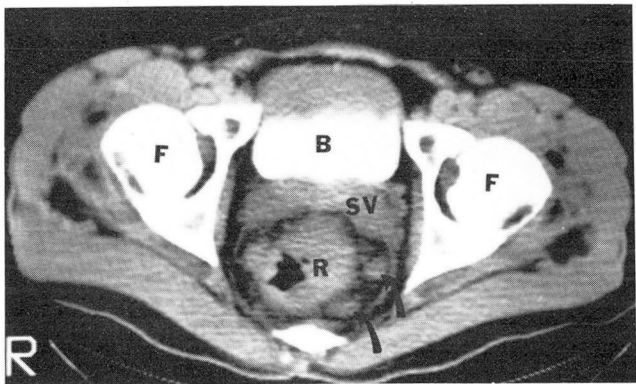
Transverse CT scan of the pelvis. Contrast media was given intravenously and was identified within the urinary bladder (B). The seminal vesicles (SV) and thickened irregular rectal wall (R) can be identified. Nodular soft tissue densities are seen in the pararectal fat (arrows); these were overlooked initially. F = femoral head.
